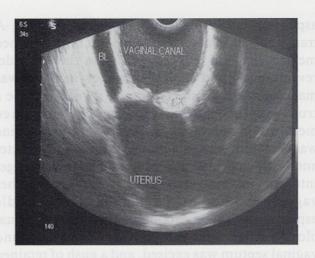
Transrectal ultrasound of the uterus, cervix, and vagina.
